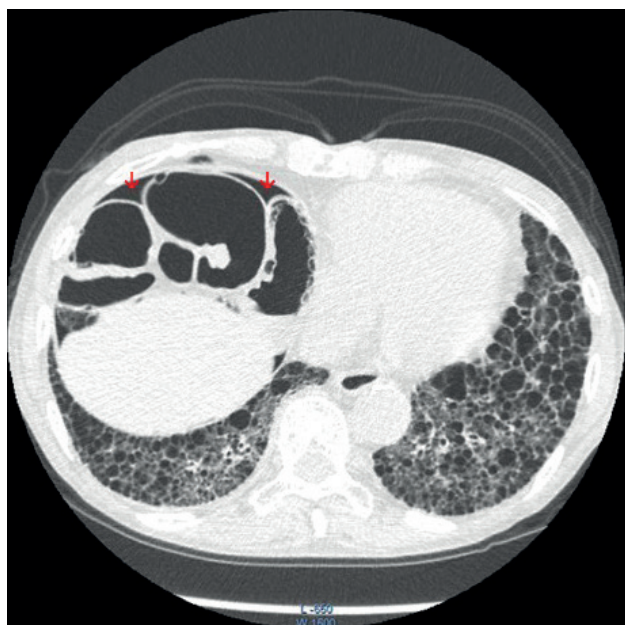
Chest CT scan reveals honeycomb opacities in both lower lung fields, intra-abdominal free air indicating pneumoperitoneum (red arrow), and dilated intestinal canals, wherein the walls contain air-filled cysts.
